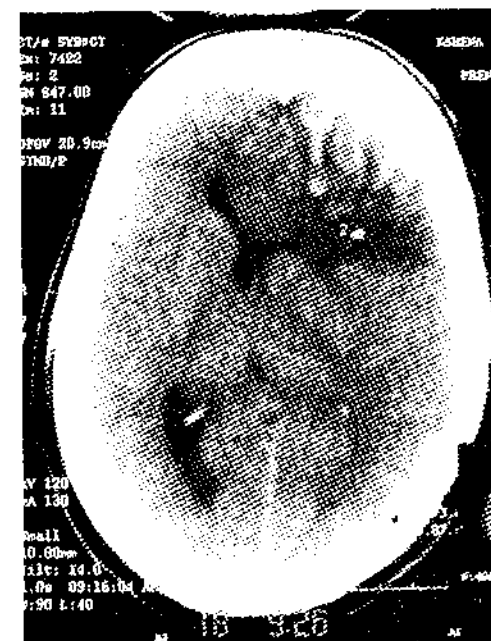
CT scan showing left frontal contusion
